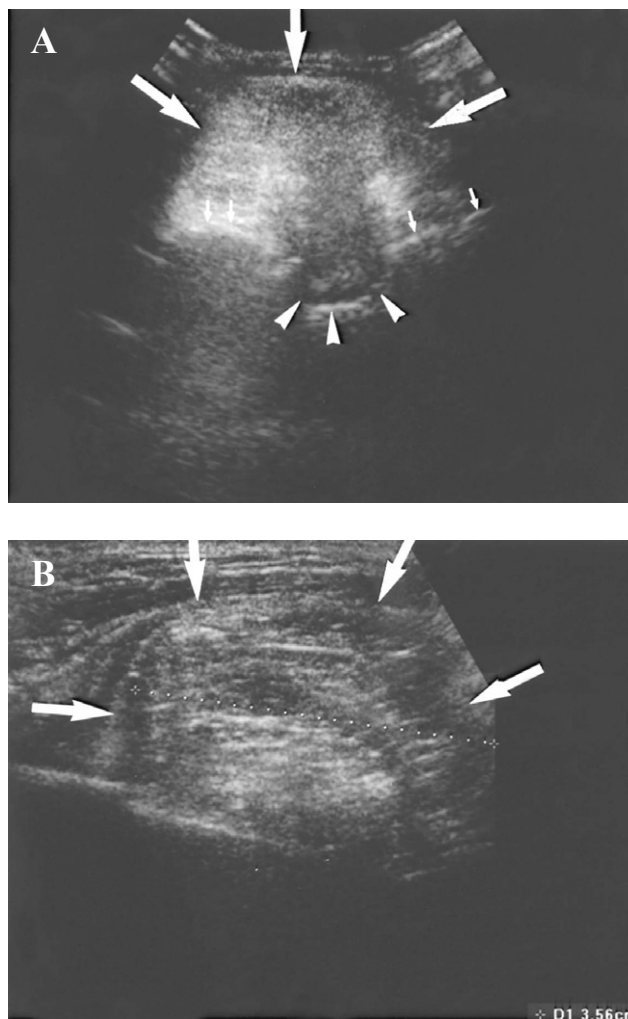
Sonography of the left elbow in the cubital region. (A) Sagittal scan using a broad band C4–8 curve array transducer demonstrates a hyperechoic mass in the proximal forearm (large arrows) just anterior to the proximal radius (small arrows). The bony cortex of the proximal radius is interrupted (arrowheads). The left-hand side of the figure corresponds to the forearm of the patient. (B) High-resolution ultrasound using a broad band L6–12 linear array transducer demonstrates the fine detail of the lesion. There are some echogenic streaks in the echogenic mass (arrows), suggesting a lipomatous tumor. (C) Color Doppler ultrasound shows color flow signals on the margin in the peripheral zone of the tumor (arrows).
